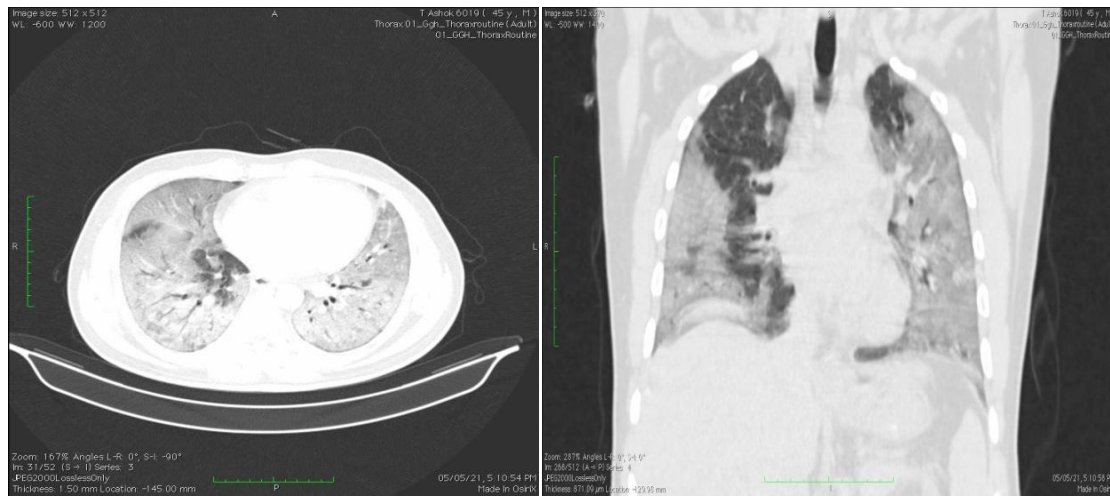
CT chest: shows bilateral multifocal subpleural and peribronchial ground glass opacites and reticulation -crazy-paving appearance
